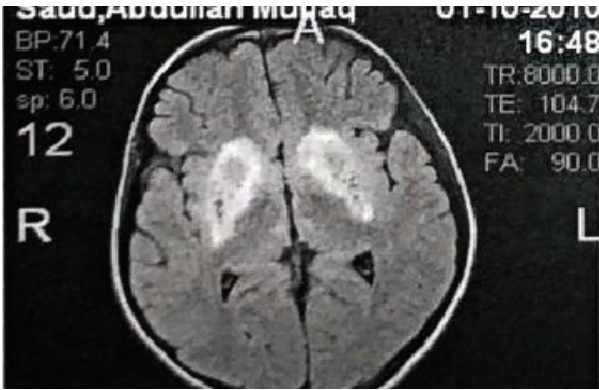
MRI of the patient's brain.
